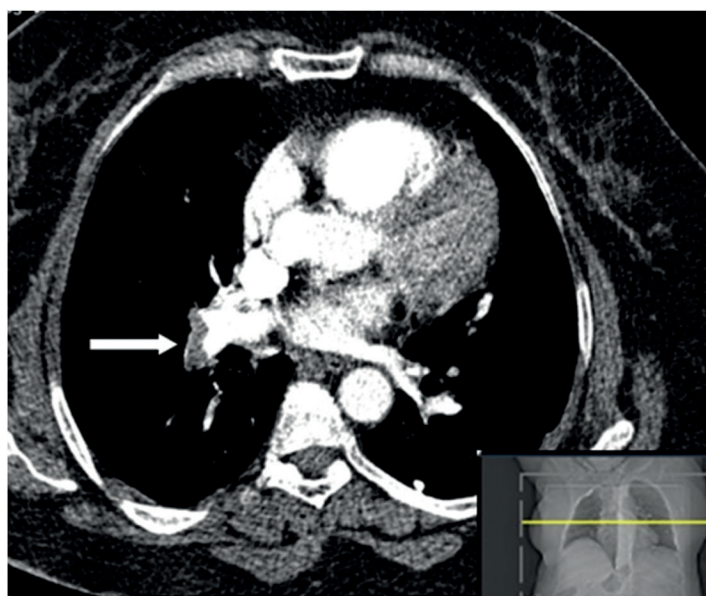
At the axial section of thorax computed tomography, the area consistent with thrombus that causes filling defects in the right main pulmonary artery is indicated by arrow.
